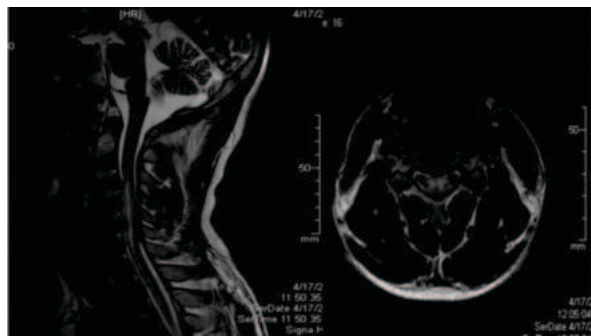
A and B - MRI CERVICAL SPINE- taken second day of the onset of symptoms shows T2 hyperintensity extending from the C3 to T1 levels, with a predominantly anterior segment resembling a pencil-like hyperintensity.
